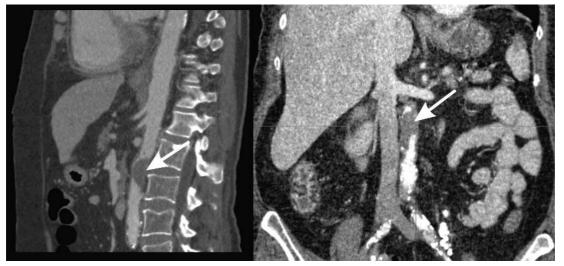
Frontal (right panel) and sagittal (left panel) reconstructions of contrast enhanced abdominal computed tomography. Thrombus in abdominal aorta is marked by white arrows
